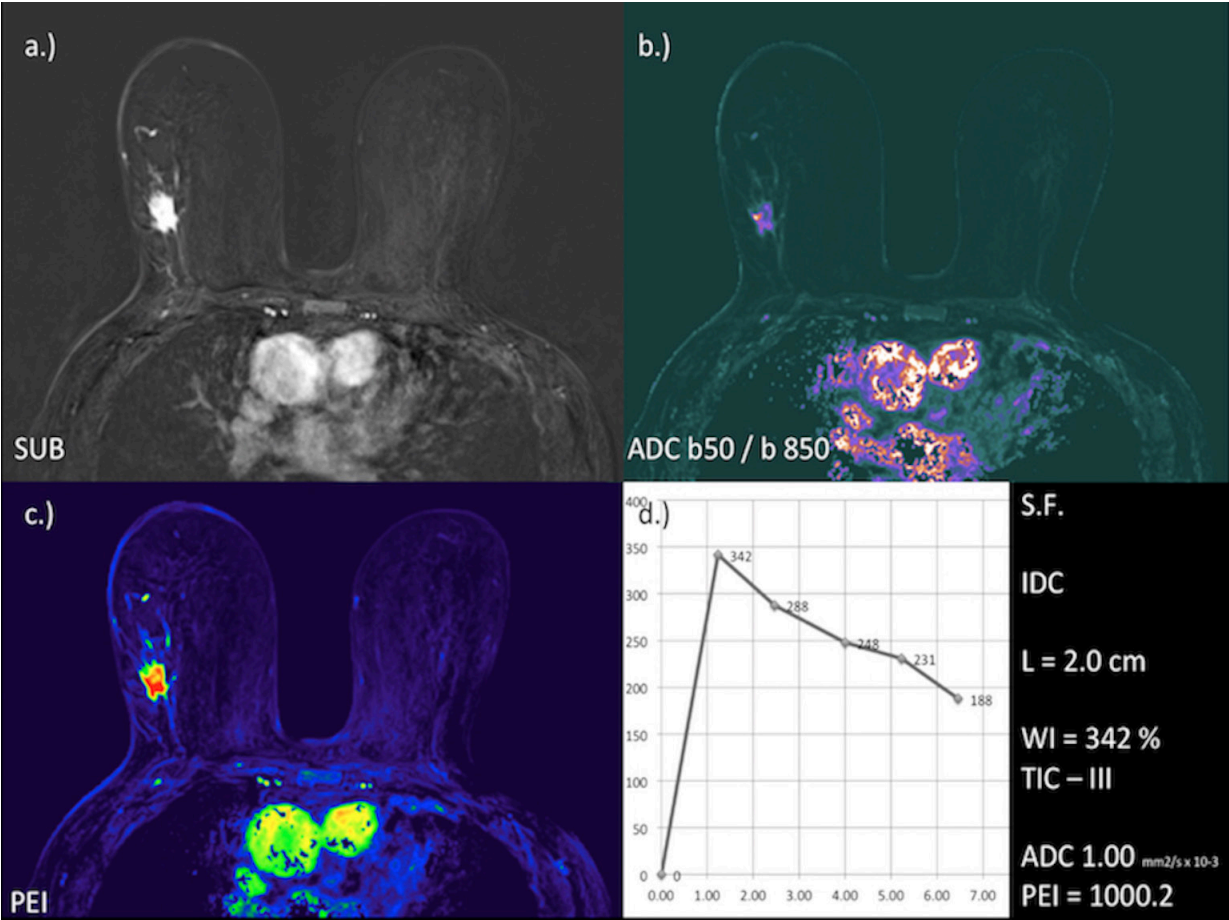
Morpho-dynamic and functional parameters of a 62-yr. old patient (S.F.) with IDC. (a) DCE-MRI, Subtraction (b) Diffusion Coefficient (ADC). (c) Positive Enhancement Integral (PEI). (d) Time-intensity curve.
